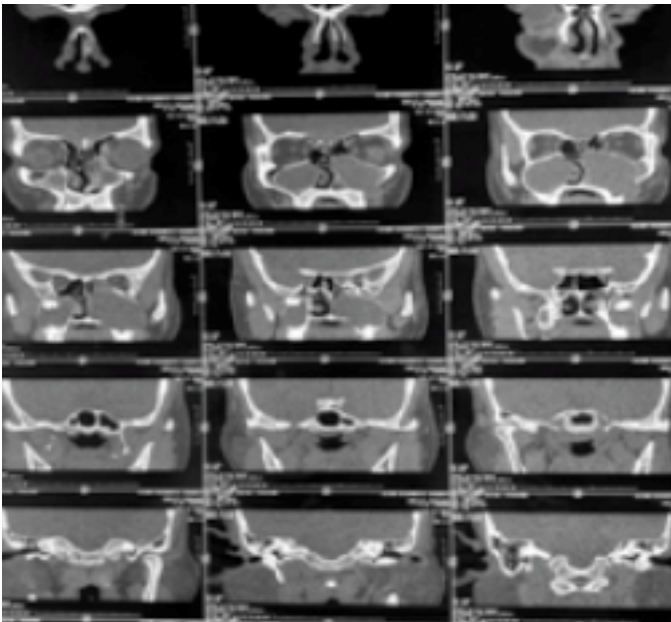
Preoperative CT scan PNS showing disease
